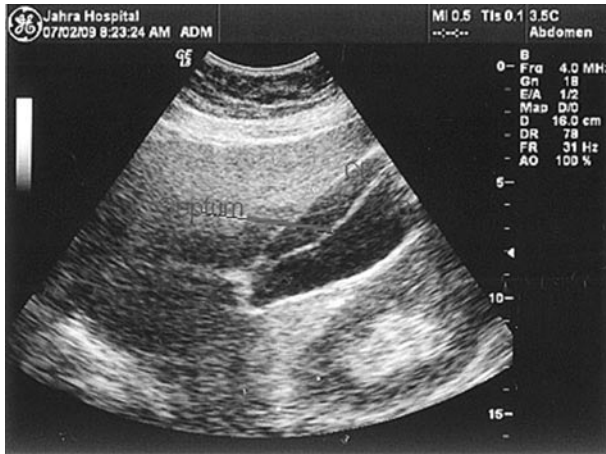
Preoperative ultrasound showing septated gall bladder
